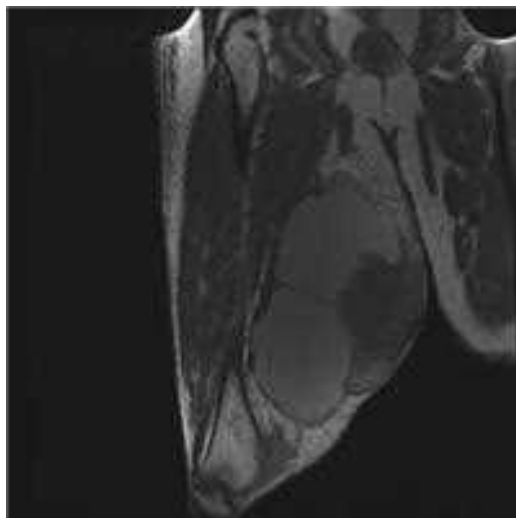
A 62-year-old man presented with right thigh pain. Magnetic resonance imaging demonstrated a 20-cm high-grade sarcoma within the medial compartment.
